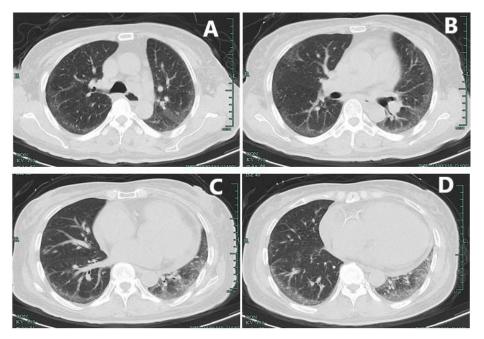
Chest computed tomography (CT) findings on admission. There was interstitial pneumonia on the bilateral lung fields and right ventricular dilation
